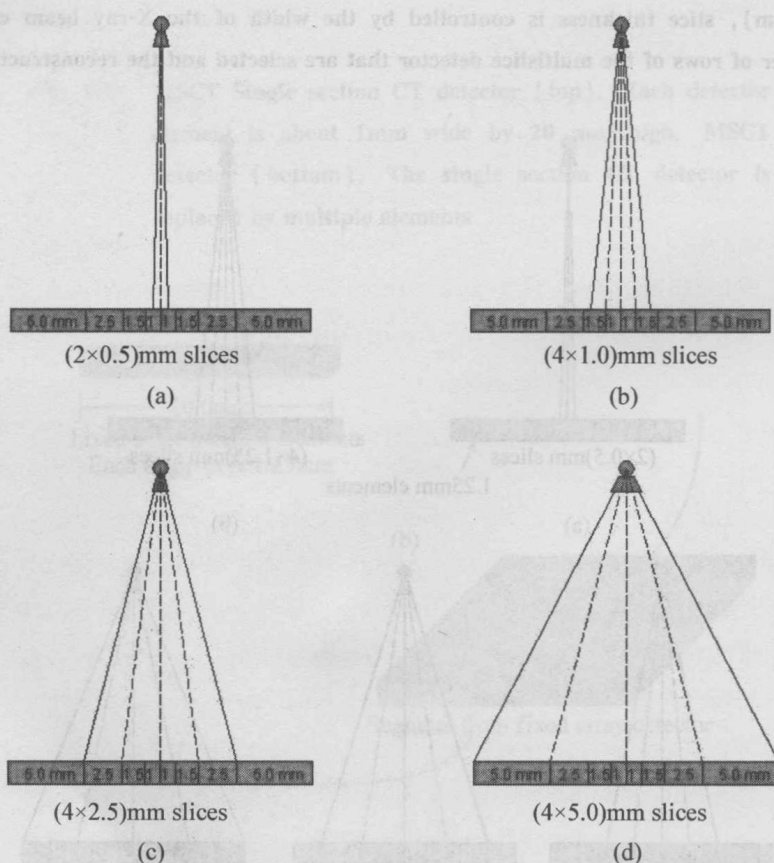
MSCT Examples of variable slice width for the four slices acquired with an adaptive multislice CT detector. (a) The two central detectors are irradiated with a fraction of the X-ray beam forming two 0.5 mm slices. For the remaining figures (b-d), the beam width is increased to produce four slices, and the slices are combined to give slice widths of (b) 1.0 mm, (c) 2.5 mm, and (d) 5.0 mm
